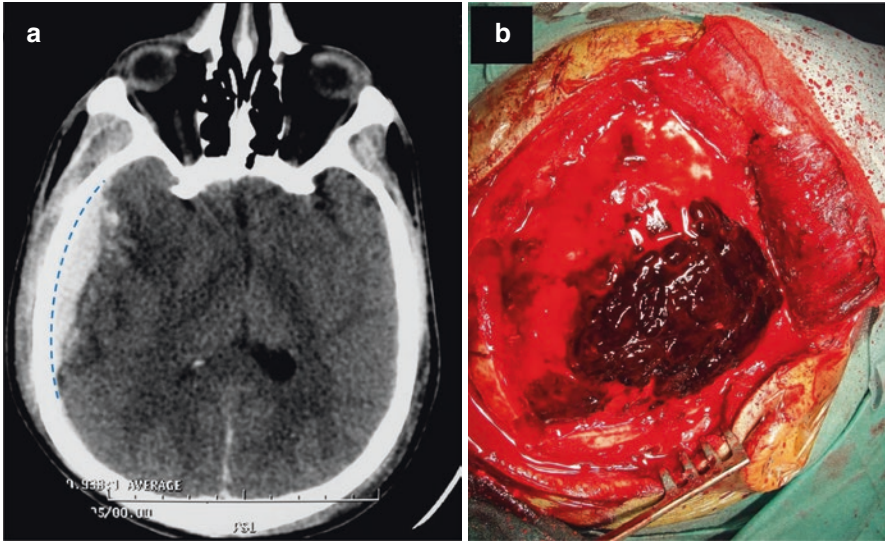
Axial CT-scan: post-traumatic acute temporal extradural hematoma on the right side (a). Operative view after removing the bone flap: the acute hematoma (blood clots) was revealed on the epidural (b)
